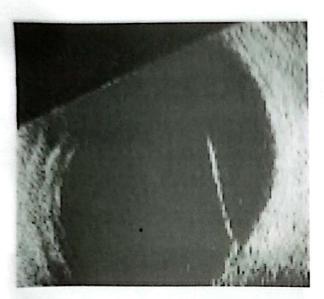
Vitreous band causing traction on the retina as seen on B-scan Ultrasonography
